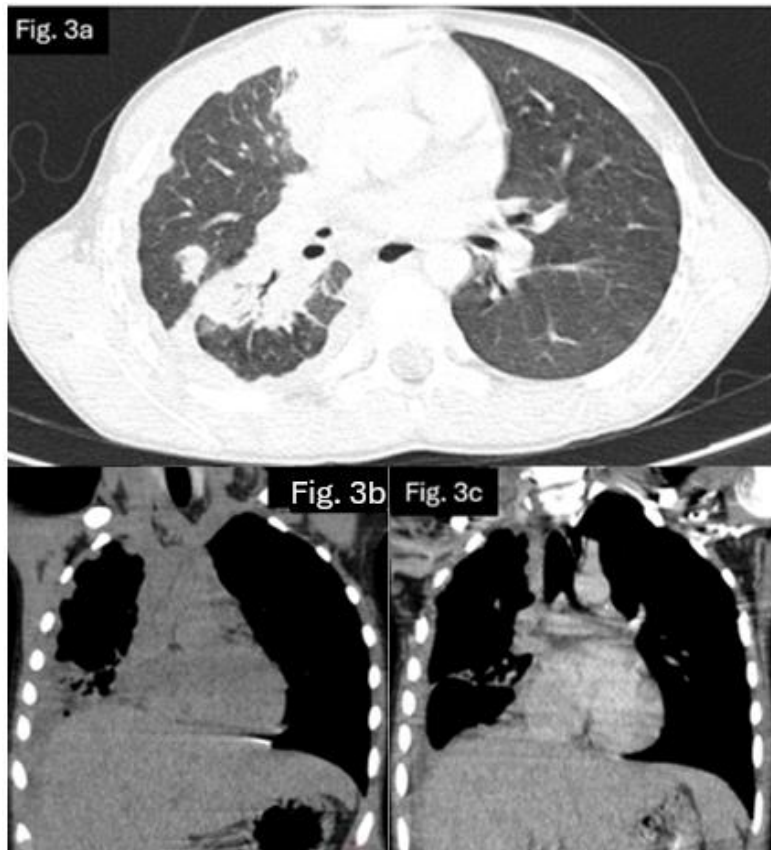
a. CT Chest lung window Images showing consolidation. b. Plain and c. post contrast images in mediastinal window images showing diffuse circumferential nodular right pleural thickening.
